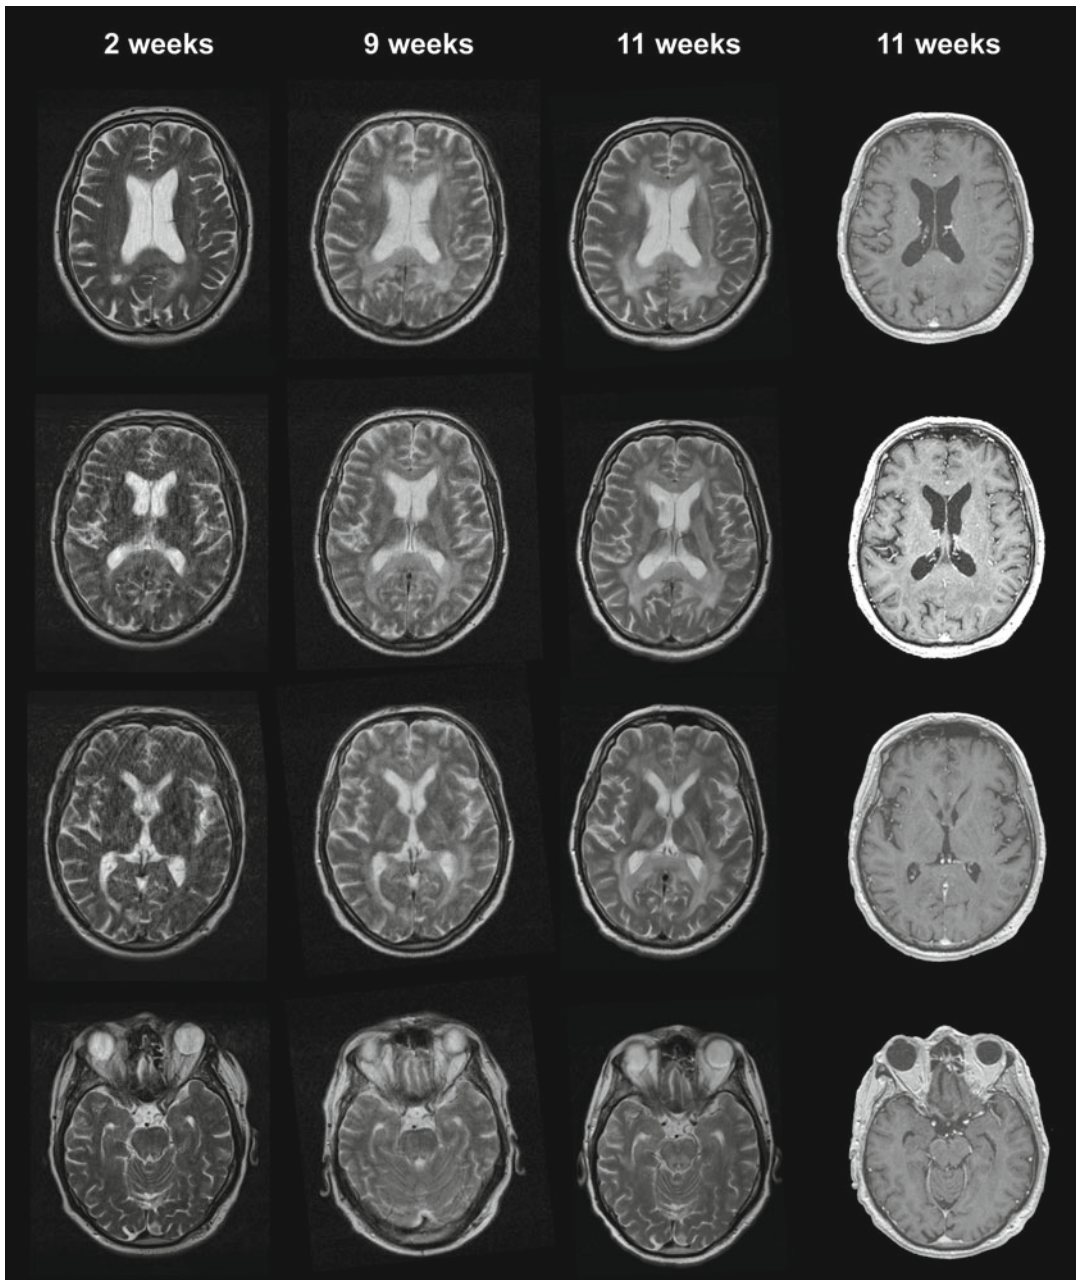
Upper rows:* T2-weighted MR images (2 mm slice thickness) in corresponding levels showing progressive and confluent white matter hyperintensities involving the corpus callosum and both thalami. No contrast
